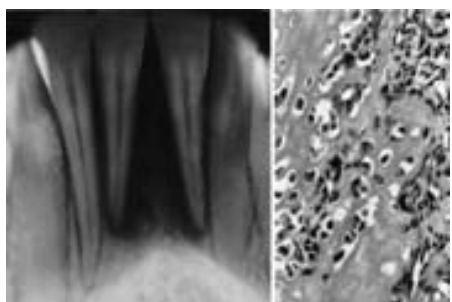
Periapical radiolucencies associated with mandibular incisors. Note that the lucency extends coronally along lateral periodontal ligament spaces and that the lamina dura is ill-defined. The biopsy (right), which shows atypical cells making tumor bone, was diagnosed as osteosarcoma.
